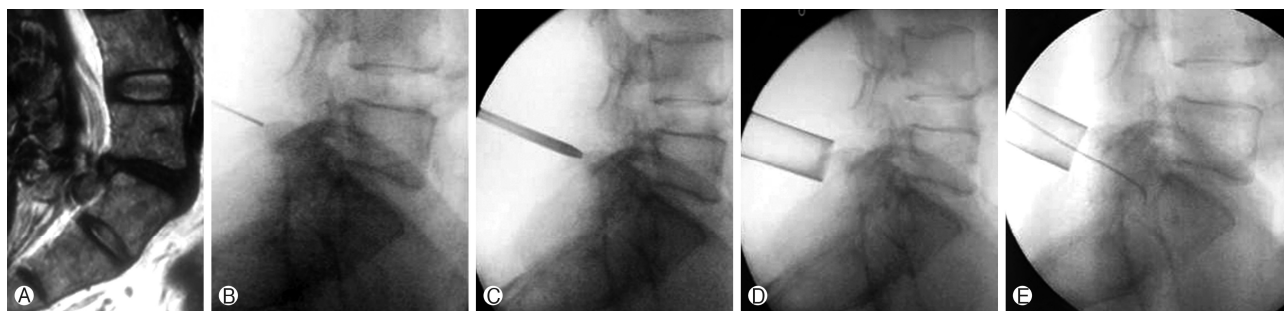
(A) Pre-operative MRI showing Sacralisation of last lumbar vertebra, (B) A spinal needle is first inserted at desired level (C) Progressive dilators are passed, (D) Radiograph after docking the tube, (E) Penfield at the pedicle showing satisfactory decompression.
